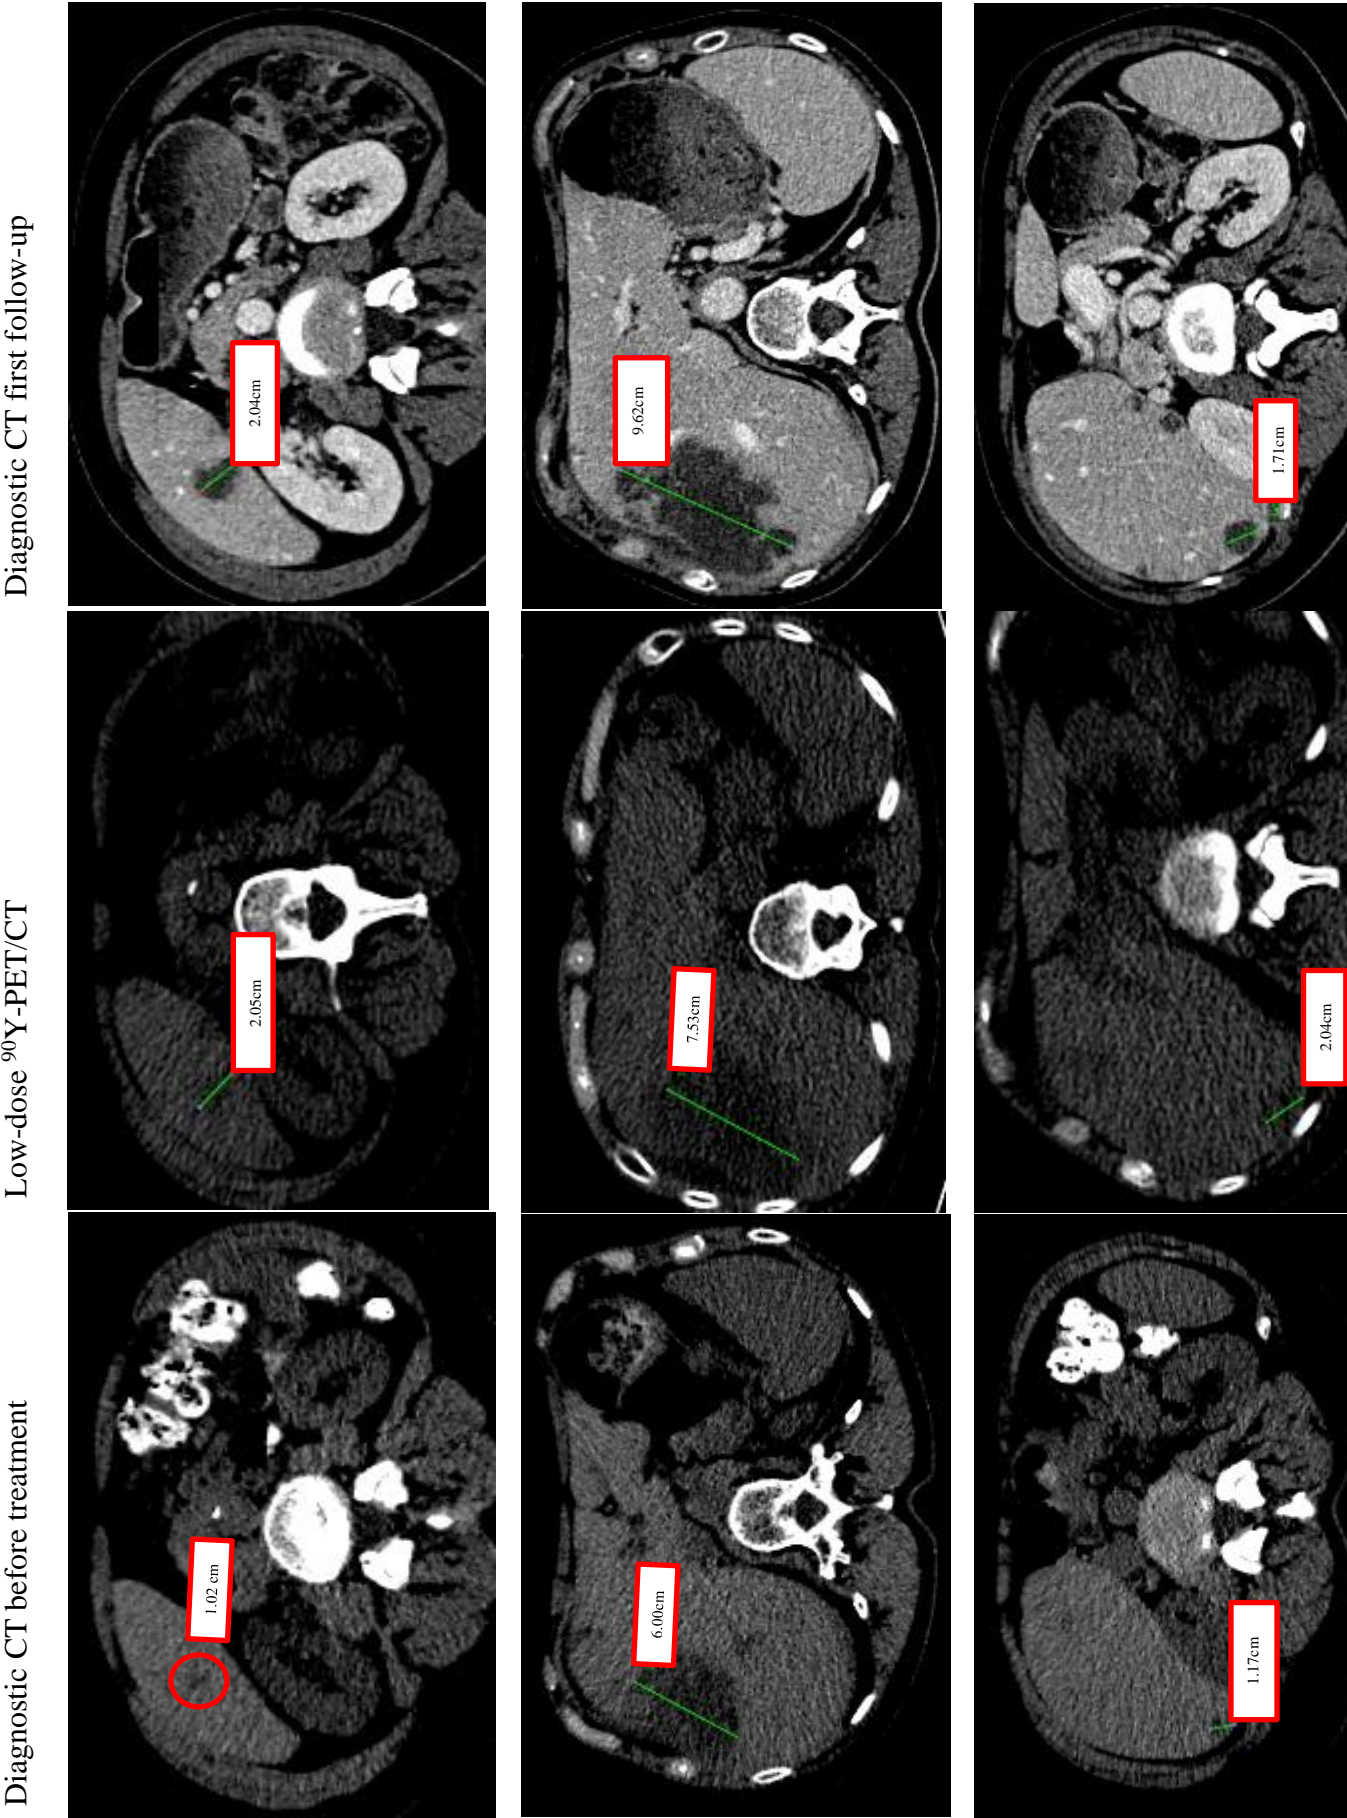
Difference in lesion size for three lesions between the diagnostic CT made before treatment (left), low-dose CT (⁹⁰Y-PET/CT) (middle) and diagnostic CT at the first follow-up (right)/
